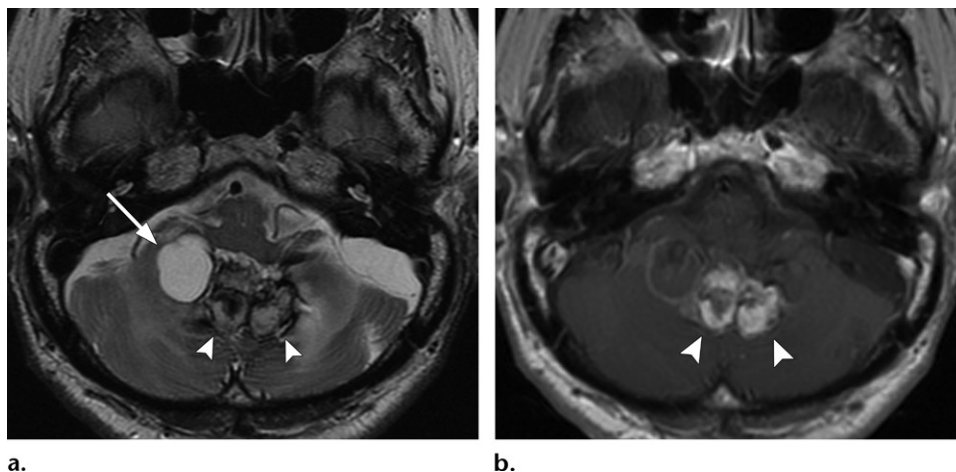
Chronic expanding encapsulated hematoma in a 75-year-old man who underwent stereotactic radiosurgery for a cerebellar arteriovenous malformation 24 years earlier. (a) Axial T2-weighted image shows a cyst (arrow), a chronic hematoma with superficial siderosis (arrowheads), and perilesion edema in the irradiated area. (b) Axial contrast-enhanced T1-weighted image shows disruption of the blood-brain barrier (BBB) within the hematoma as enhancement (arrowheads).
